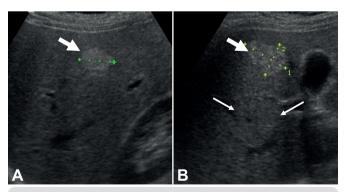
Typical hemangioma on ultrasound. A and B) Well-defined, homogeneous and hyperecogenic nodule (thick arrows) with posterior acoustic enhancement (thin arrows) and no signal on Doppler scan. (courtesy of Dra. Iara R. S. Lucena, Hospital de Clínicas, Porto Alegre, Brazil)
